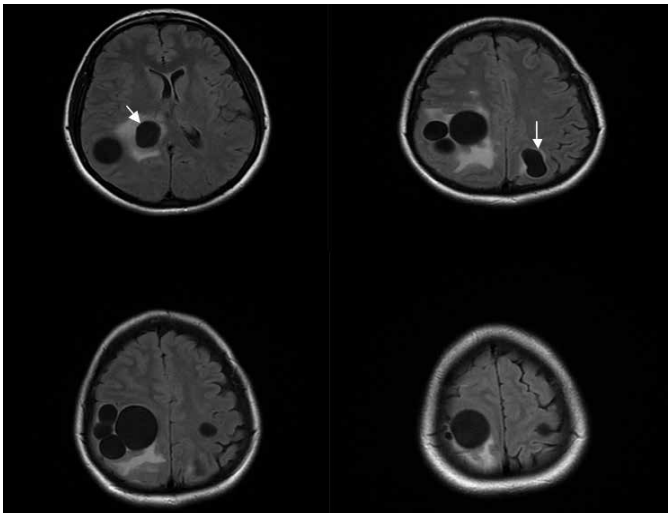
Multiple intraaxial cystic masses, some of which are multilocular, are seen in both hemispheres in the axial FLAIR and T2 images. One cyst in each side on the parietal lobes have thickened walls and surrounding edema whereas others do not have edema (the ones that do have edema are marked with arrows).
